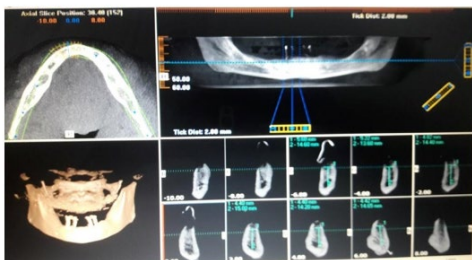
Cone beam showing length and width of bone using radiographic stent
